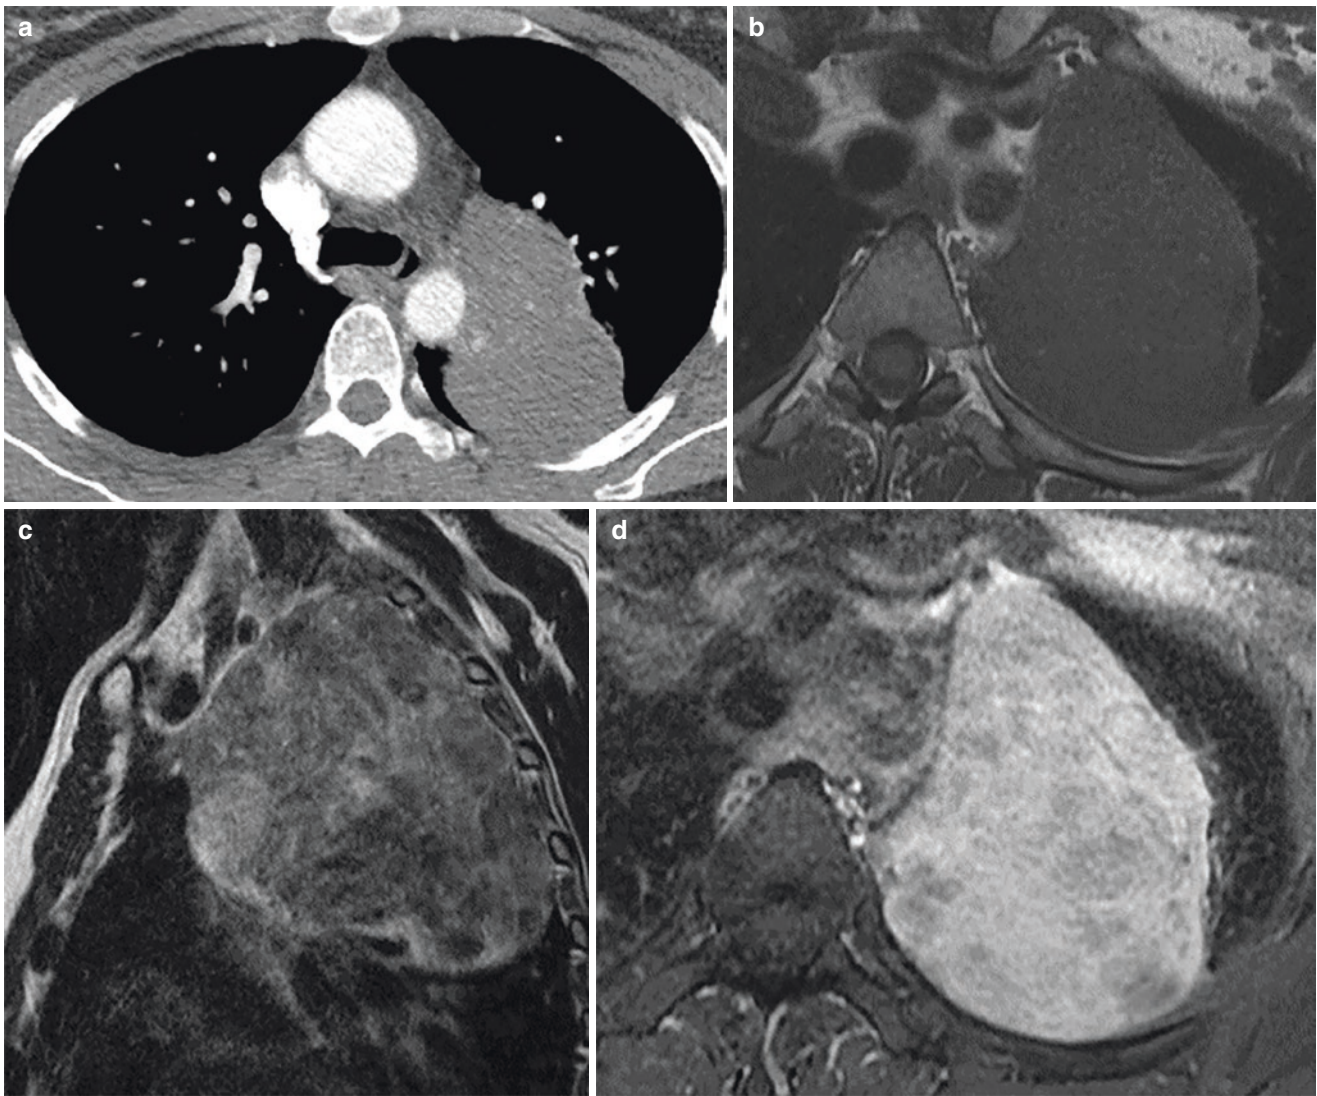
(a) Axial CT shows homogeneous soft tissue mass in the posterior left upper hemithorax along the oblique fissure, (b) axial T1-weighted MRI shows the mass has low signal intensity, (c) sagittal
